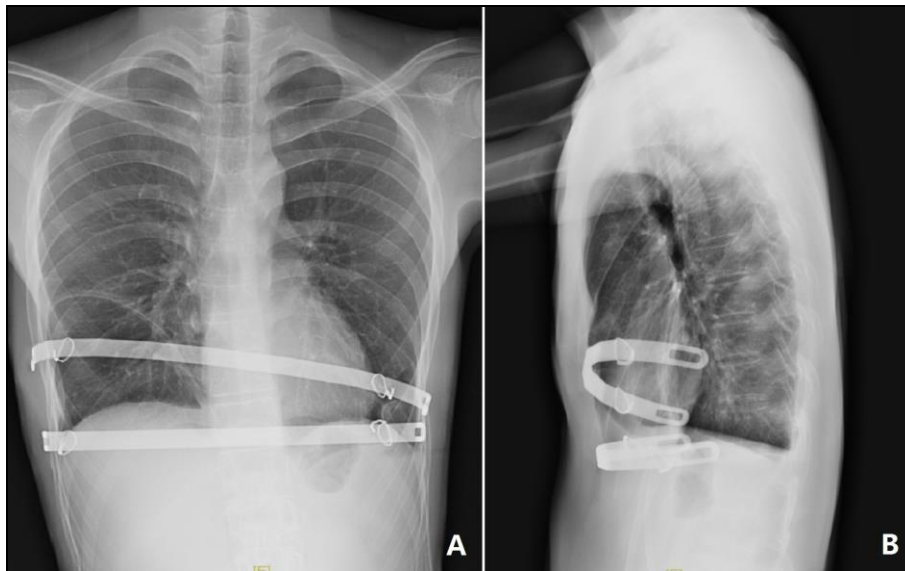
Postoperative X-ray examination. The position of the steel bars were normal, and the chest wall deformity disappeared.
